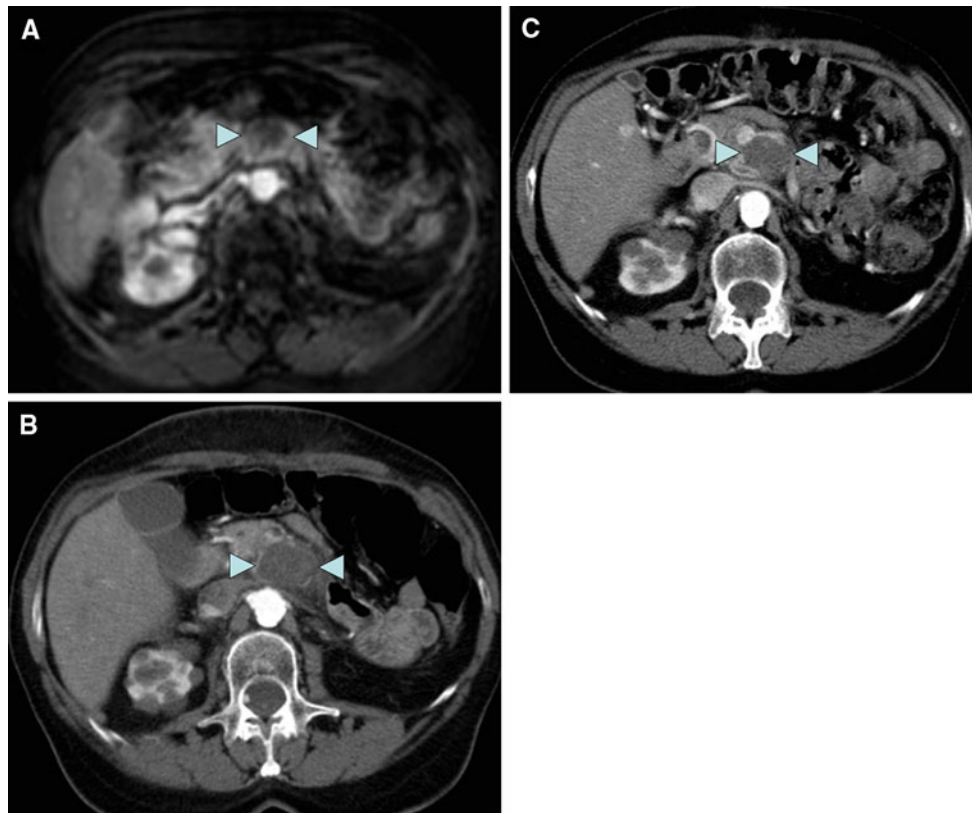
Patient no. 2. A MRI after administration of contrast medium, performed before HIFU ablation, shows a 2.4-cm lesion of in the body of the pancreas that enhances peripherally (*arrowheads*). B MDCT performed 24 h after HIFU ablation shows ablation of entire lesion, as defined by the lesion’s hypodensity and lack of enhancement, without
